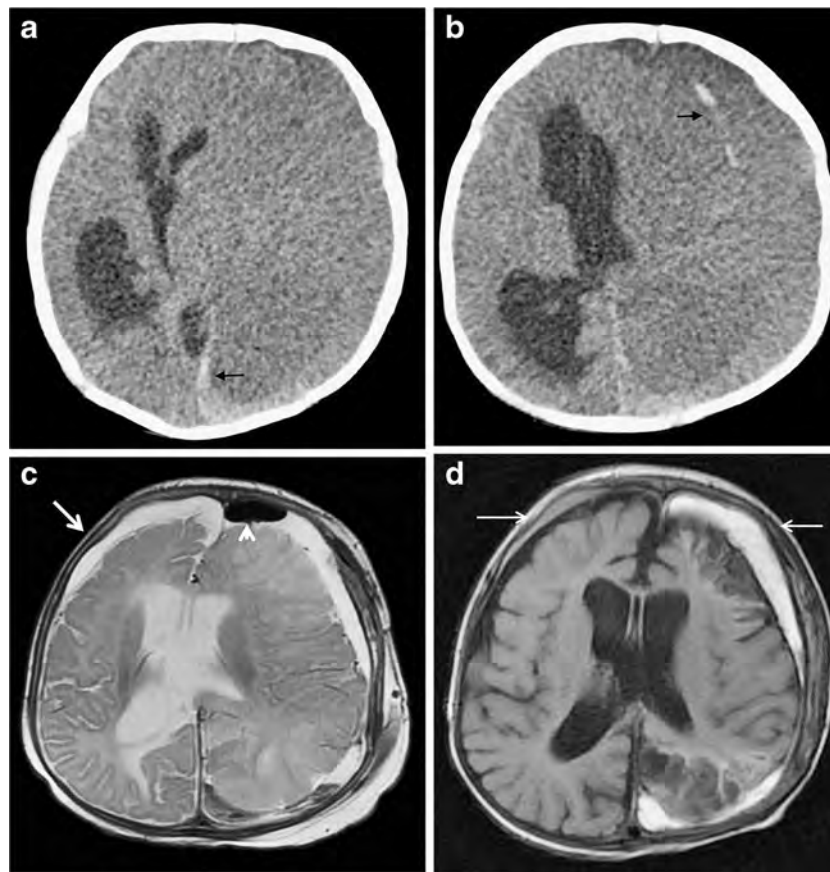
No age-different pattern despite the father admitting to several previous episodes of violent shaking, slaps and impacts to this 3-month old boy presenting with seizures and hemiplegia. A rapid increase in head circumference was noticed over the previous 2 weeks. a, b Initial CT shows a large, low-density subdural hematoma with areas of mild hyperdensity (*arrows*) located over the left hemisphere and in the inter-hemispheric fissure. Major compression and displacement of normal structures are visible. c T2-weighted MRI a few hours after evacuation
